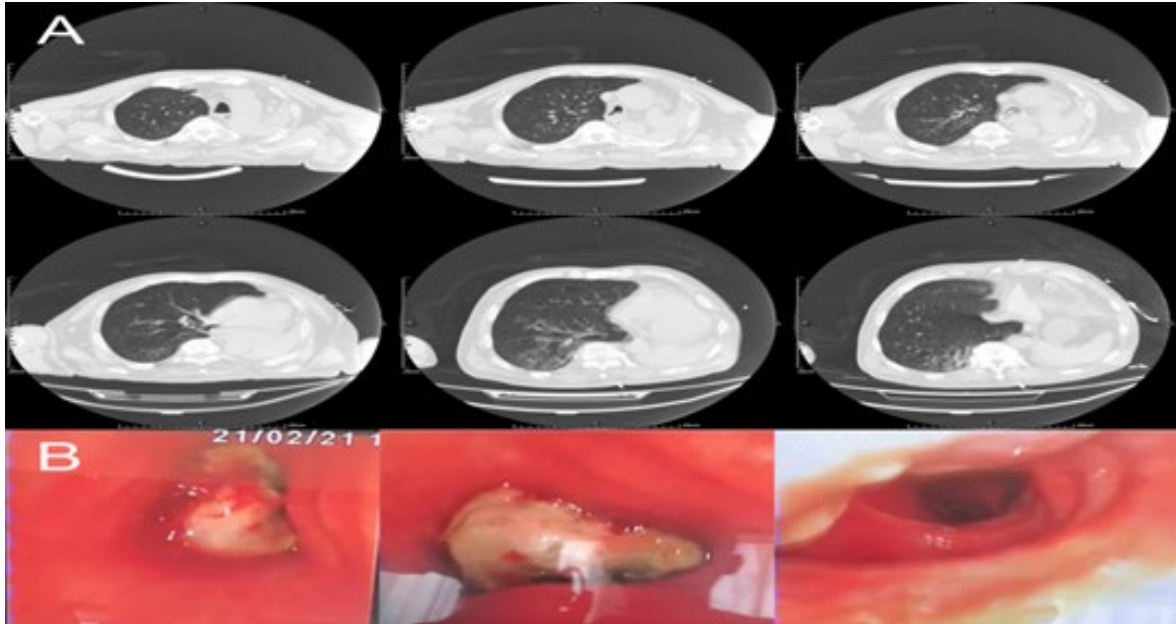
Thoracic computed tomography and bronchoscopy images prior to surgery. A: Computed tomography revealed a tumor on the tracheal wall causing left bronchial obstruction; B: Bronchoscopy revealed complete occlusion of the left main bronchus.
